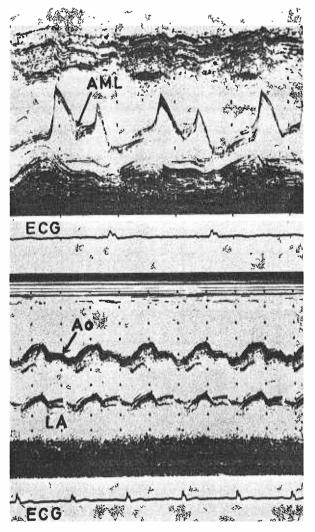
Echocardiogram after removal of left atrial myxoma. Ao = Aorta. LA = Left Atrium. (See text).
